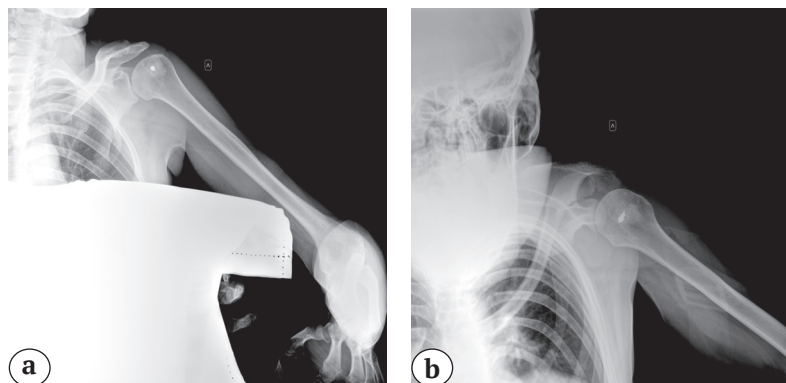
Shoulder X-rays in AP (a) and axial (b) views; impacted bone graft and titanium anchor fixator
